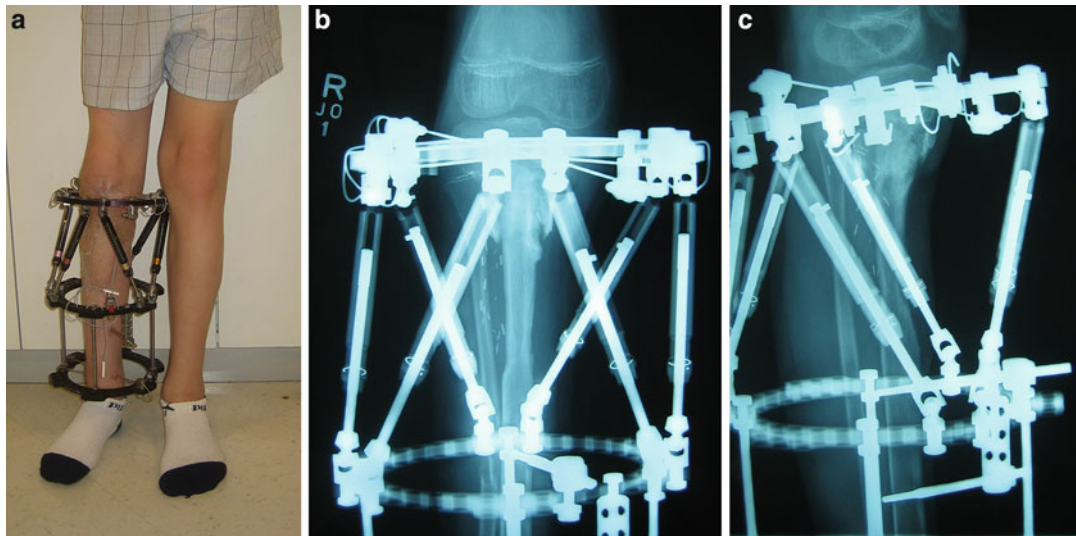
(a) Clinical photo in the TSF 1 month after surgery. (b) AP and (c) lateral X-ray showing deformity correction in the frame. There are four multi-planar wires in the proximal tibia
